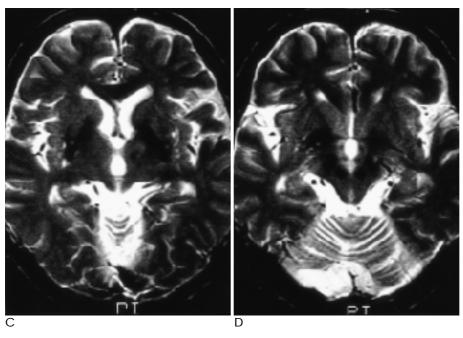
A. Sagittal T1-weighted image shows loss of ventral bulging of the olive and pons, indicating of severe atrophy. The atrophy of the cerebellum and cerebrum is also noted.
